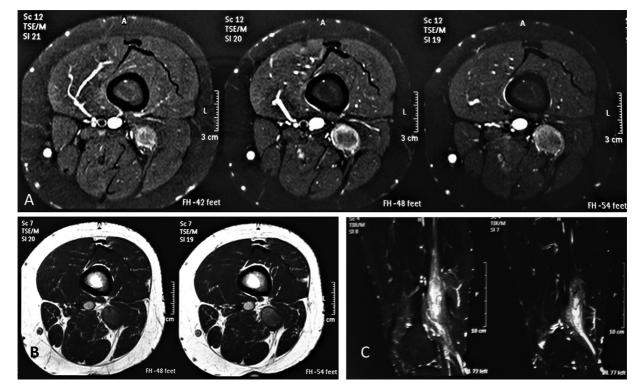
(A) T1-weighted magnetic resonance imaging (MRI) in axial sections showing uptake of the contrast, more intense at the periphery. (B) T1-weighted MRI in axial sections showing regular lesion of well-defined limits without invasion of neighboring planes and without surrounding edema. (C) T2-weighted short tau inversion recovery (STIR) MRI in sagittal sections showing sciatic nerve damage in the topography of its bifurcation.
